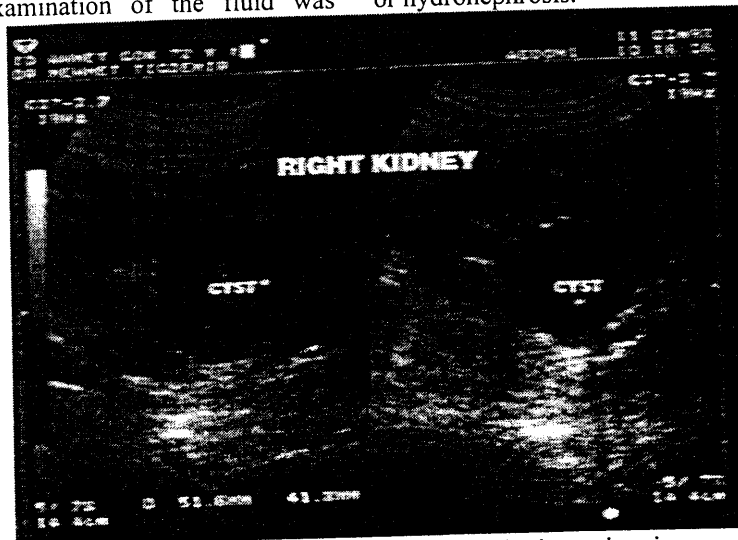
Ultrasonography showing cyst and hydronephrosis.
